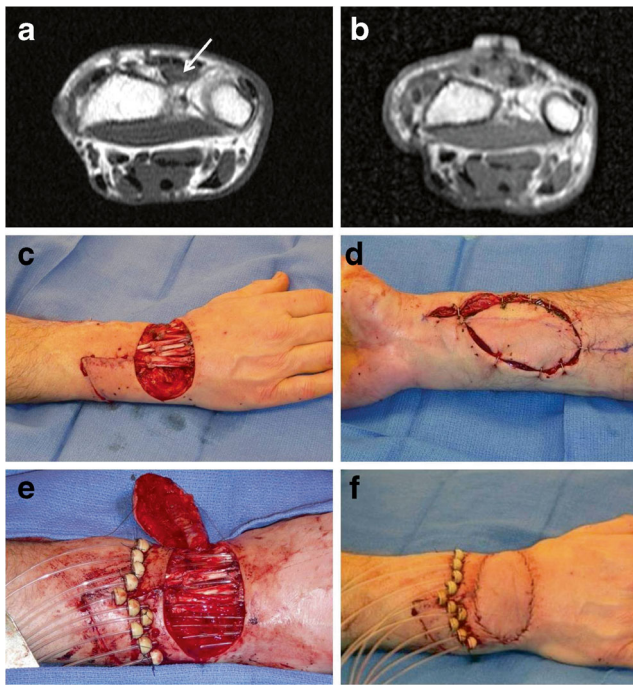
Distal upper extremity reconstruction (patient 12). a Preoperative T1-weighted MRI imaging of a clear cell sarcoma (*arrow*) immediately deep to the hand extensor tendons. b T1-weighted MRI 4 months after surgery demonstrating complete sarcoma resection without recurrence. c Intraoperative view following clear cell sarcoma resection and reconstruction of extensor tendons with allograft tendons. d A pedicled radial artery flap was utilized for soft tissue coverage. e Brachytherapy catheters positioned prior to closure. f On-table result
